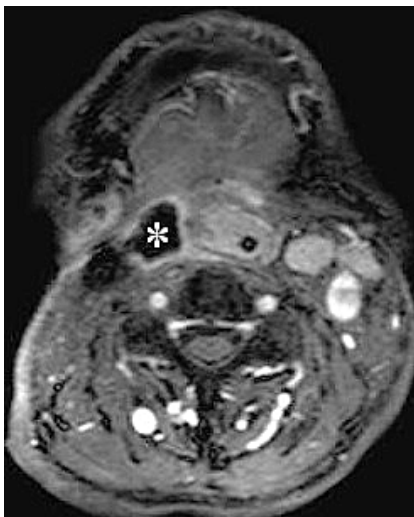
A contrast-enhanced MRI image fourteen months after the embolization shows abscess formation (asterisk) with ring-enhancement.
